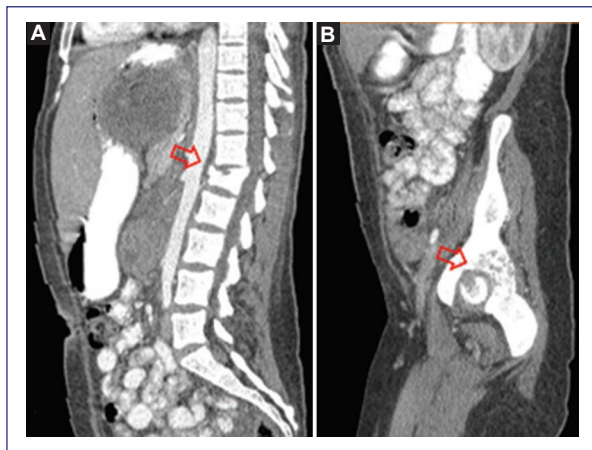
Sagittal computed tomography showing. A: metastasis to the L1 vertebral body with compression fracture (arrow), and B: metastasis to the right acetabulum with cortical destruction and a permeative pattern (arrow).
